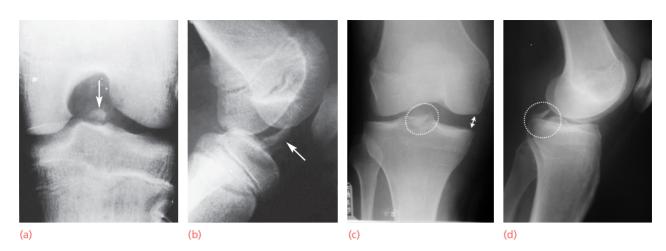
Bony avulsion fractures (a,b) AP, lateral X-rays showing a large, displaced avulsion fracture of the tibial spine consistent with a bone ACL injury. This young man injured his knee while playing football. (c,d) AP and lateral X-rays showing a bony avulsion of the PCL.
